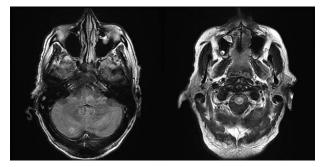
Magnetic resonance imaging of the brain (T2 flare image) showing punctate lesion in the right cerebellum and in the pons, representing a tuberculoma.
